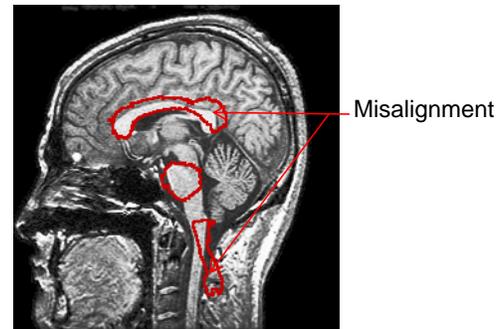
A cross-section of a subject's brain MRI overlaid with computed segmentation from an intensity correspondence based registration method.
